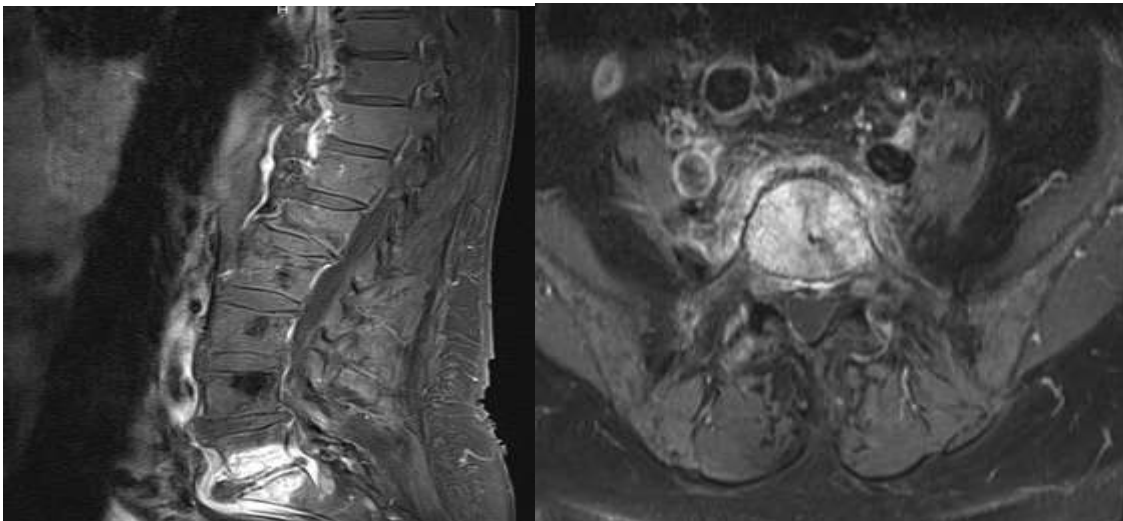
Lumbar MRI showing an appearance compatible with acute L5-S1 spondylodiscitis in the early phase with infiltration of the soft tissues.
